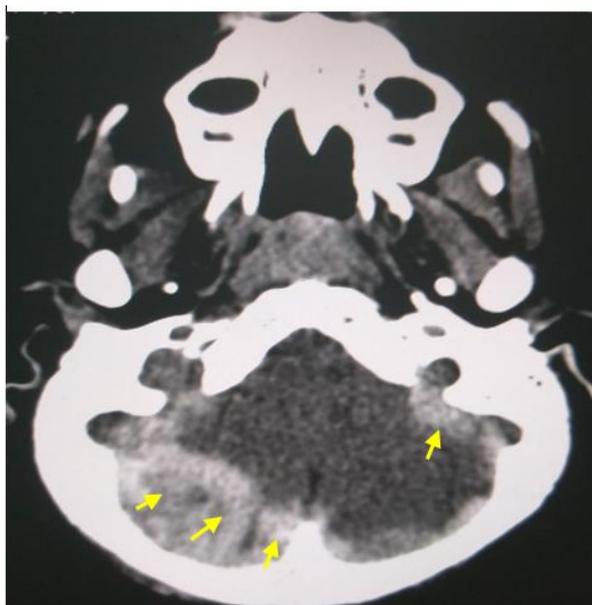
Brain CT axial section: Posterior fossa hematoma, more prominent on the right (yellow arrow)
